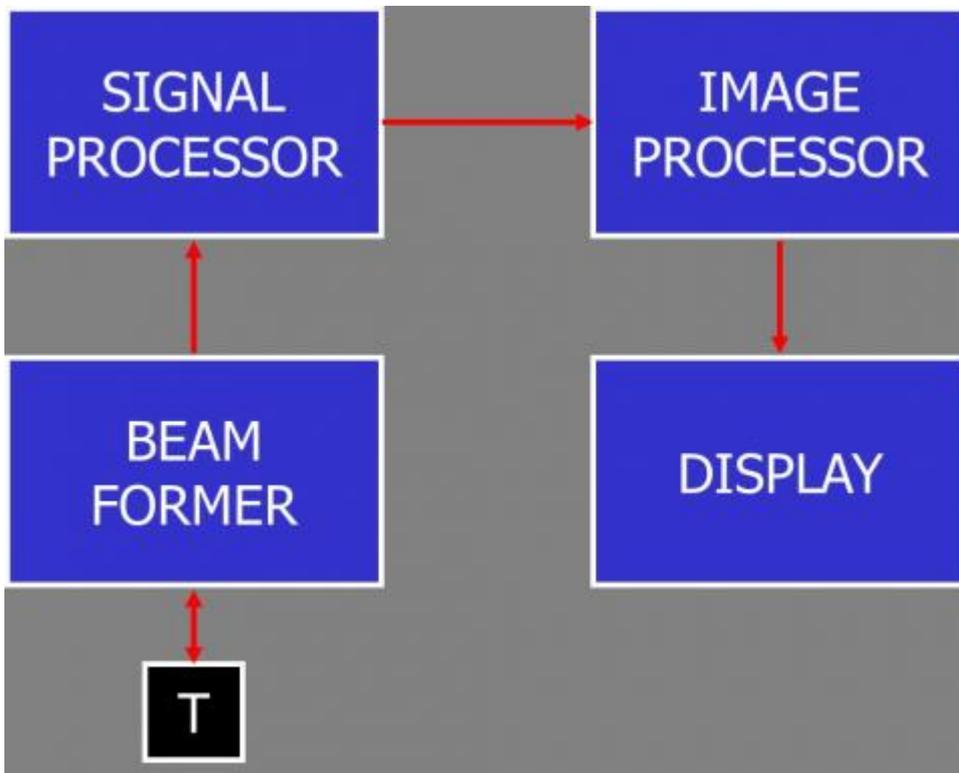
Organization of a sonographic instrument.
